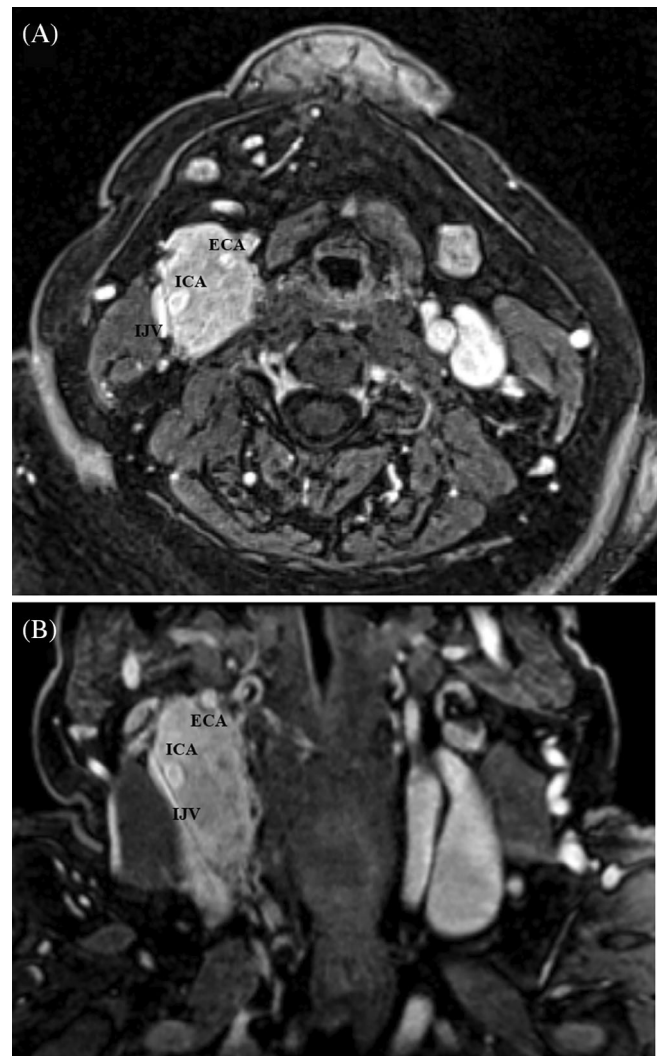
(A,B) Axial and coronal views of T1-weighted contrast-enhanced MR of a 58-year-old woman with a 4.5 cm Shamblin III CBT of the right side of the neck, symptomatic for pain since 1 year. Both external (ECA) and internal (ICA) carotid arteries, as well as internal jugular vein (IJV) and common (CCA) carotid artery, were anatomically preserved during surgical removal. Levels IIA lymph nodes were dissected and 2 out of 7 were found harboring chromaffin cells metastases. A diagnosis of MCBT was done and SDHB gene somatic mutation was diagnosed. Ga-68 DOTANOC PET/CT scan was negative for multifocal and/or distant metastases. Adjuvant radiotherapy was not performed after multidisciplinary discussion and patient's counseling. She is alive without loco-regional or distant relapse 28 months after surgery.
